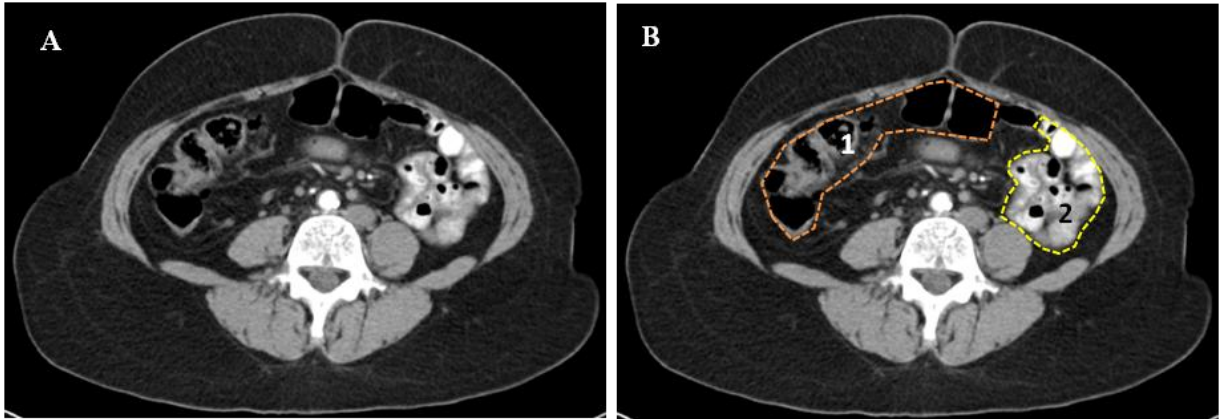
A. CT scan of the whole abdomen with IV and oral contrast (axial section). B. Axial cut labeled as follows: (1) large bowels, (2) small bowels
